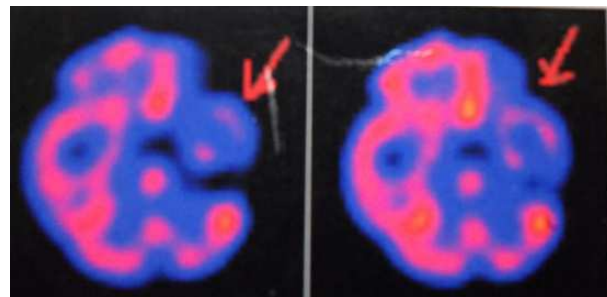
A,B.SPECT before treatment: Severe hypoperfusion in the left temporal lobe (A) and frontal lobe.
